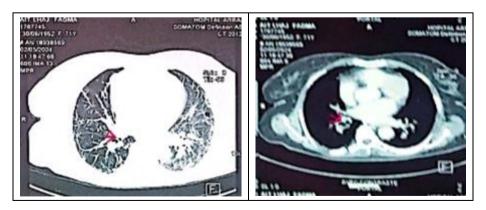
Interstitial lung disease with early fibrosis associated with a suspicious right endobronchial tissue mass on the TAP CT scan
